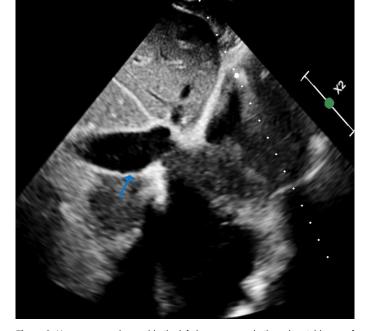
No mass was observed in the inferior vena cava in the subcostal image of transtoracic echocardiography.
